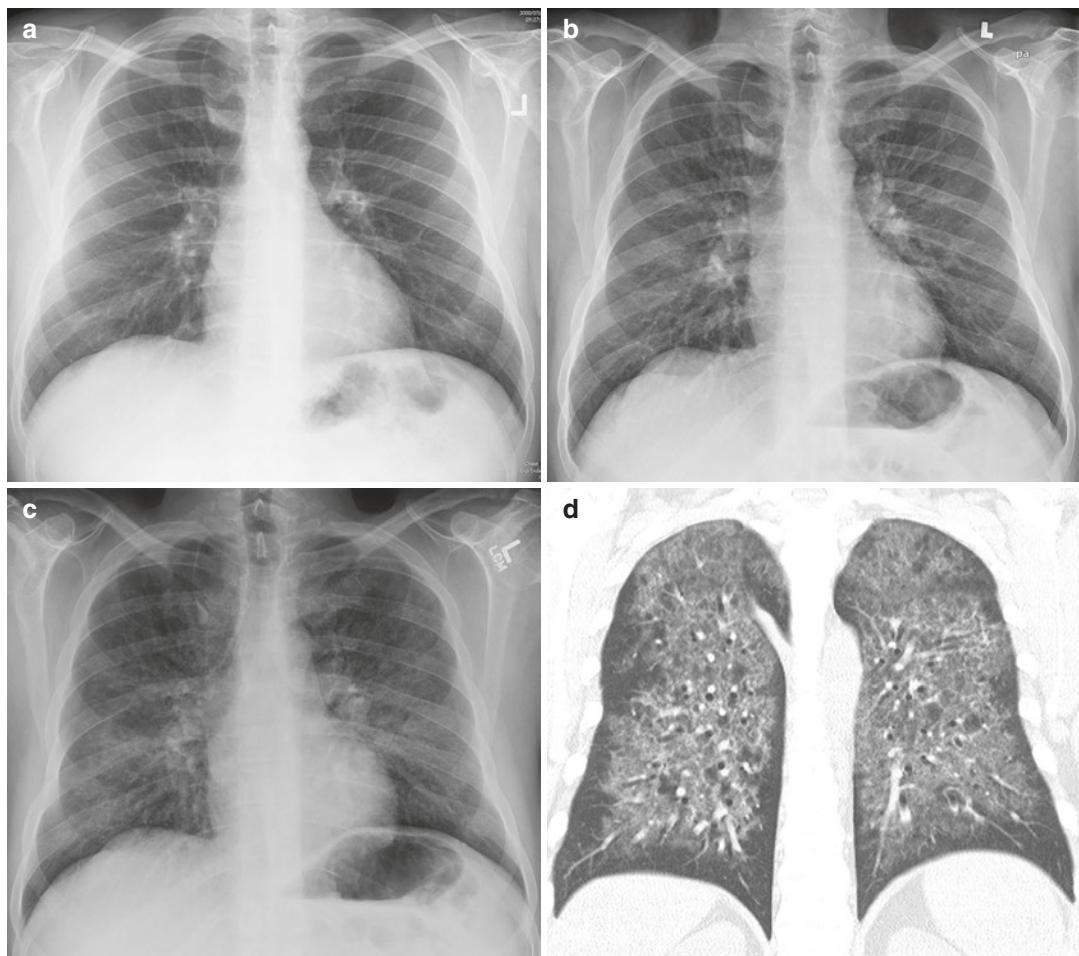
Pneumocystis jirovecii* pneumonia in a 45-year-old man not known to be immunocompromised but who was later diagnosed with HIV. Baseline PA radiograph from the prior year is normal (a). Outpatient PA radiograph for shortness of breath was reported as subtle increase in lung density diffusely (b). This is very difficult to appreciate without the prior radiograph. Emergency
